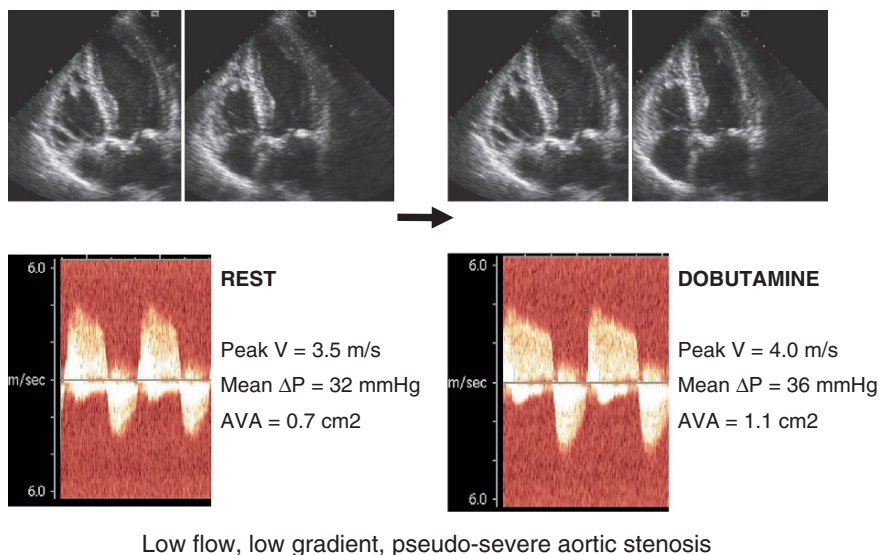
Pseudosevere aortic stenosis unmasked by dobutamine stress echocardiography in a patient with reduced left ventricular function and low gradient at rest. *Upper panels:* end-diastolic and end-systolic frames at rest (*left*) and after dobutamine (*right*), showing an increase in regional thickening. *Lower panels:* slight increase in pressure gradient (ΔP) and significant increase in aortic valve area (AVA)
